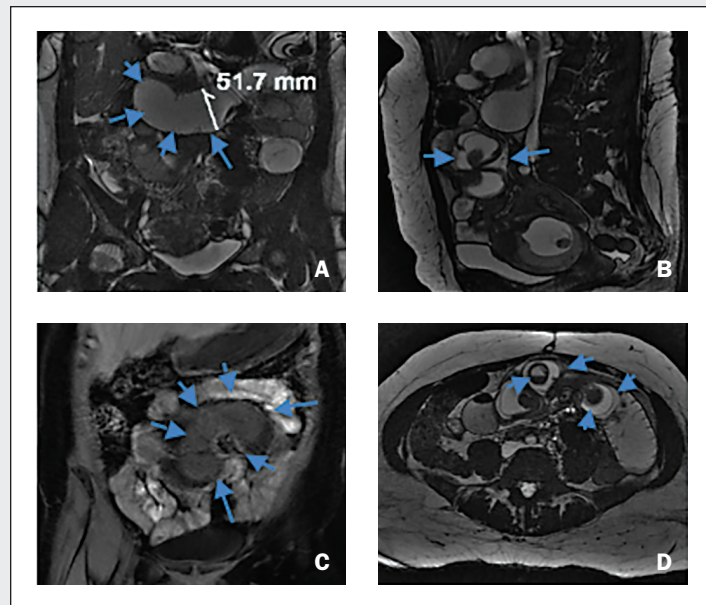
An MRI of abdomen of patient with intussusception. Telescopic sign is seen on the coronal views, A and C. Target sign is seen on both axial and sagittal views, D and B respectively.
